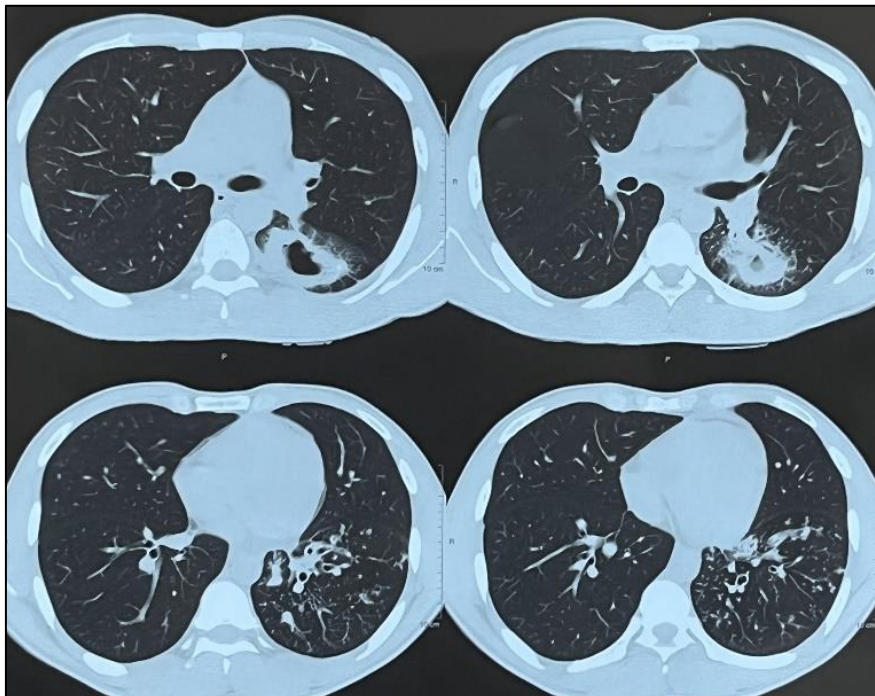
HRCT Thorax showing step ladder pattern of lung cavities
